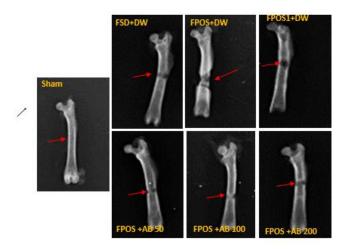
Effects of aqueous extract of Alstonia boonei on bone X-ray images
